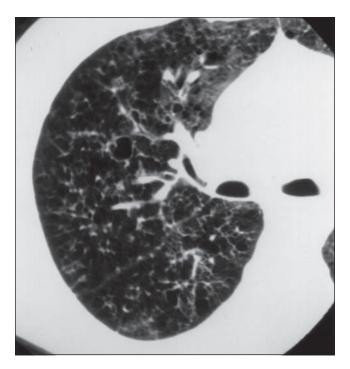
LCH. HRCT scan from the patient in Fig 3 reveals numerous cysts of various sizes throughout the lung parenchyma. Multiple small nodules can also be seen dispersed throughout the peribronchial regions and alveolar interstitium.
